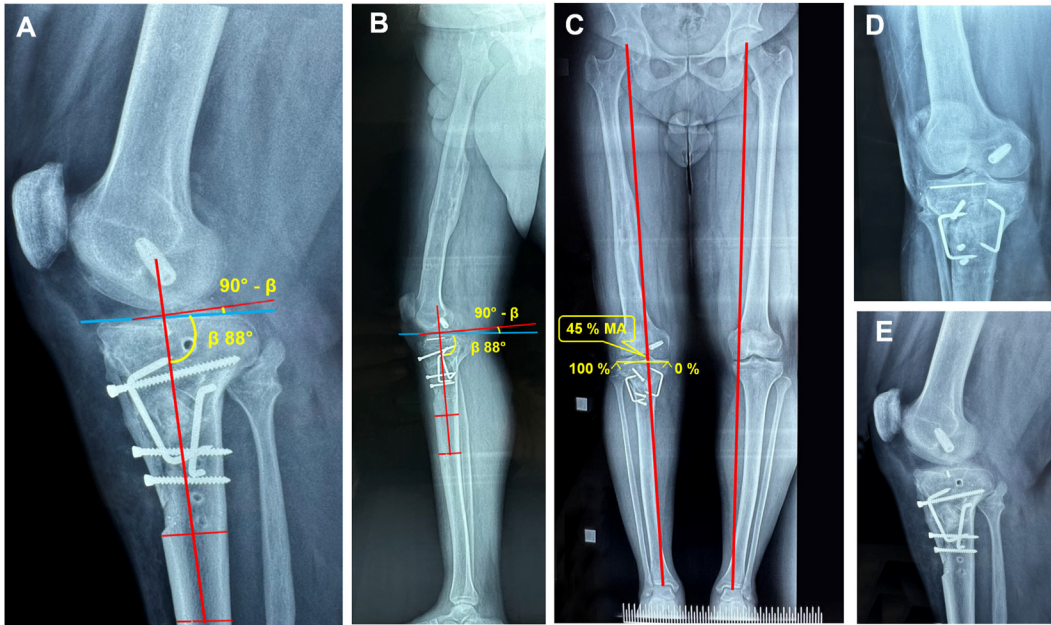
(A) Postsurgery short lateral radiograph showing 2° of posterior tibial slope (tibial diaphyseal axis $90^\circ - \beta$). (B) Postsurgery full-length lateral monopodal stance radiograph showing 2° of the posterior tibial slope (tibial diaphyseal axis $90^\circ - \beta$). (C) Postsurgery scanogram anteroposterior (AP) view showing 45% mechanical axis coronal limb alignment. (D, E) One-year postsurgery x-rays of the right knee AP and lateral views showing good union of the osteotomy and tuberosity shingle. Osteotomy healed well without any complications by the end of 6 months. The patient walked with a normal gait with no pain and subjective instability, was able to go down the stairs and ramp without any difficulty, and went back to farming. Posterior drawer's laxity became grade II from grade III. Hyperextension got reduced to 5° from preoperative 25°. The medial proximal tibial angle became 89° from preoperative 84°, and lateral distal femoral angle became 87° from preoperative 86°.
